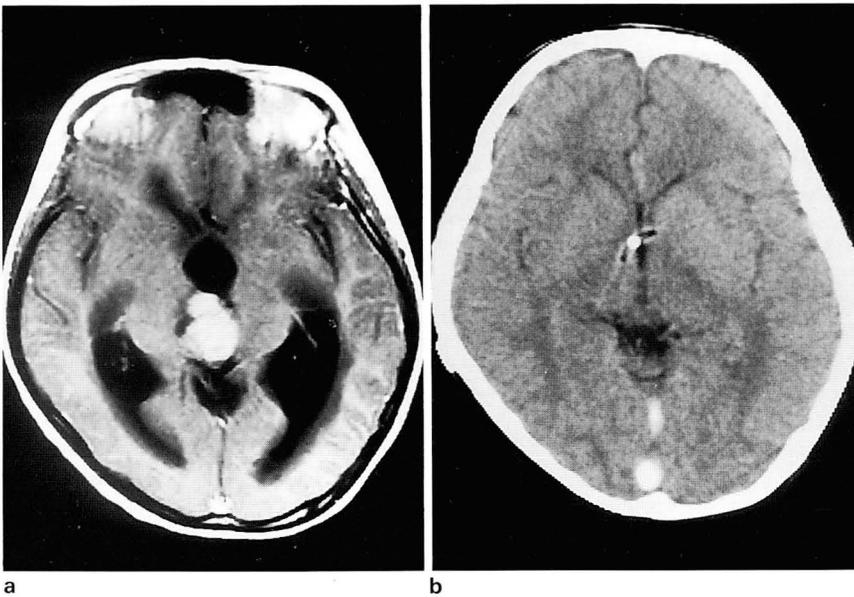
Postcontrast MR imaging(a) shows an enhancing tumor in the posterior third ventricle, causing marked obstructive hydrocephalus with periventricular edema. Postcontrast CT scan(b) 4 1/2 months following radiotherapy reveals complete resolution of the tumor.
